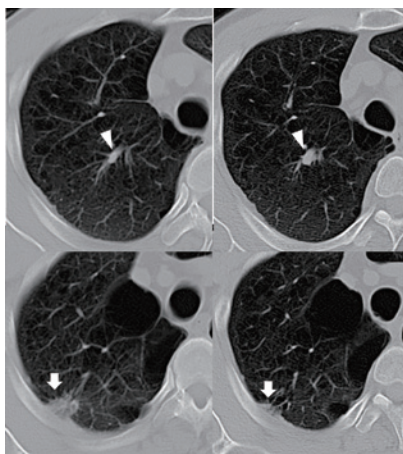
Chest CT findings
